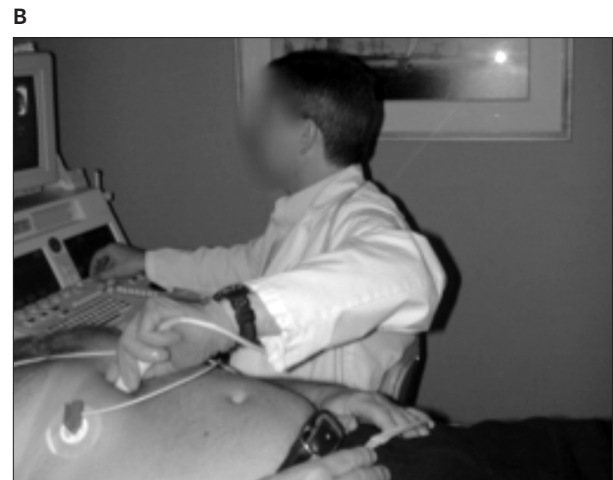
The right arm is supported and the cable is trapped in a cable brace. The vascular sonographer is looking directly at the monitor.
